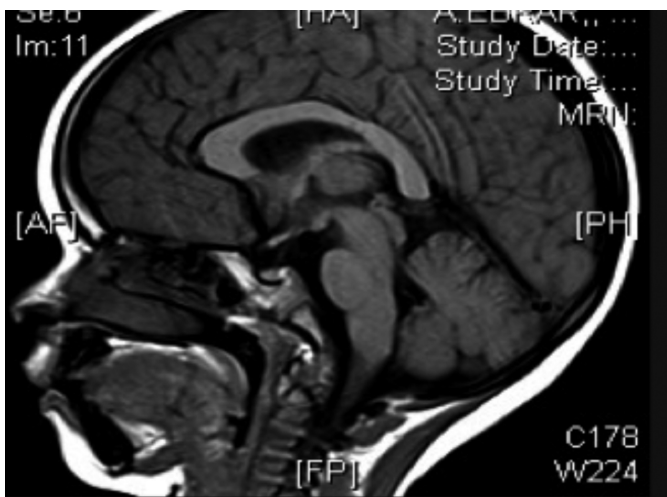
MRI brain with cerebellar degeneration.
